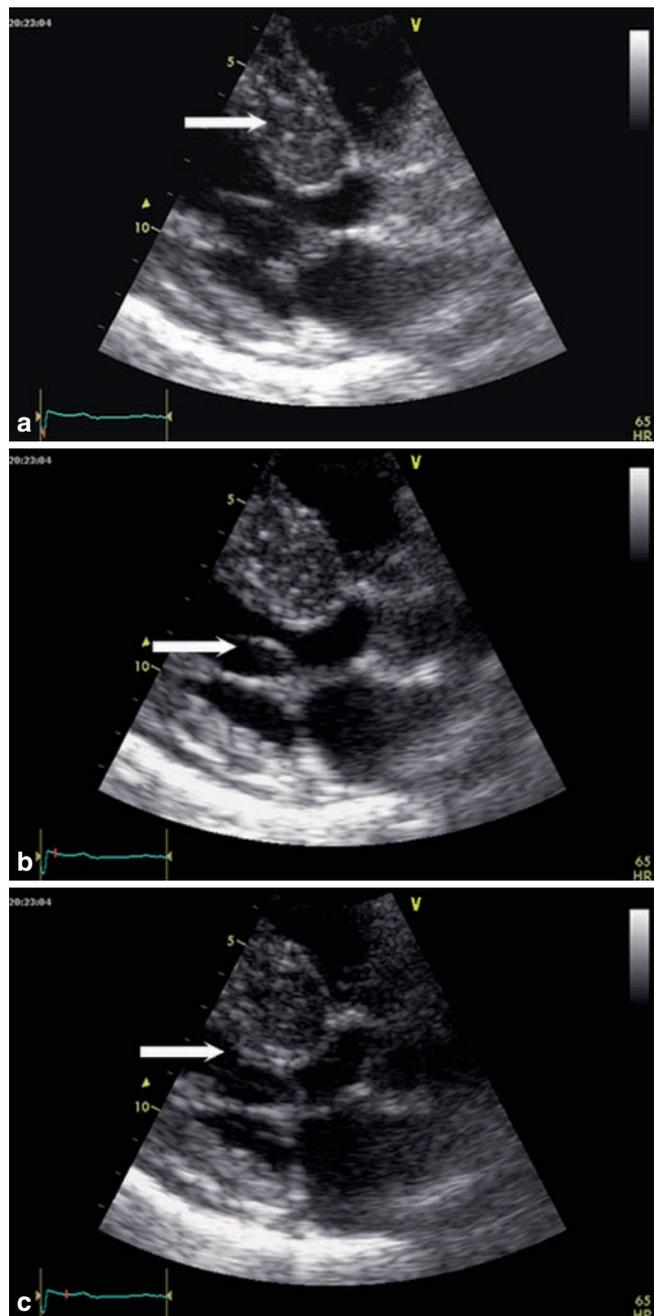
Typical example of hypertrophic obstructive cardiomyopathy. Parasternal long-axis view (zoom). (a) End-diastole: End-diastolic frame showing thickened septum (20 mm) (*arrow*). Note that the posterior wall is less thickened (12 mm). (b) Early systole: The tip of the anterior mitral leaflet (*arrow*) approaches the septum. (c) Mid-systole: Septal contact of the anterior leaflet (*arrow*). Note the narrowed outflow tract
